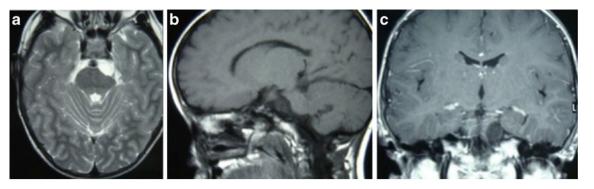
Case 1, initial presentation of patient. Left cerebellopontine angle (PCA) mass which is slightly hyperintense to CSF in axial T2-weighted imaging (\mathbf{a}), slightly hyperintense to CSF in sagittal T1-weighted imaging (\mathbf{b}), and shows no enhancing in coronal T1 contrasted imaging (\mathbf{c})
